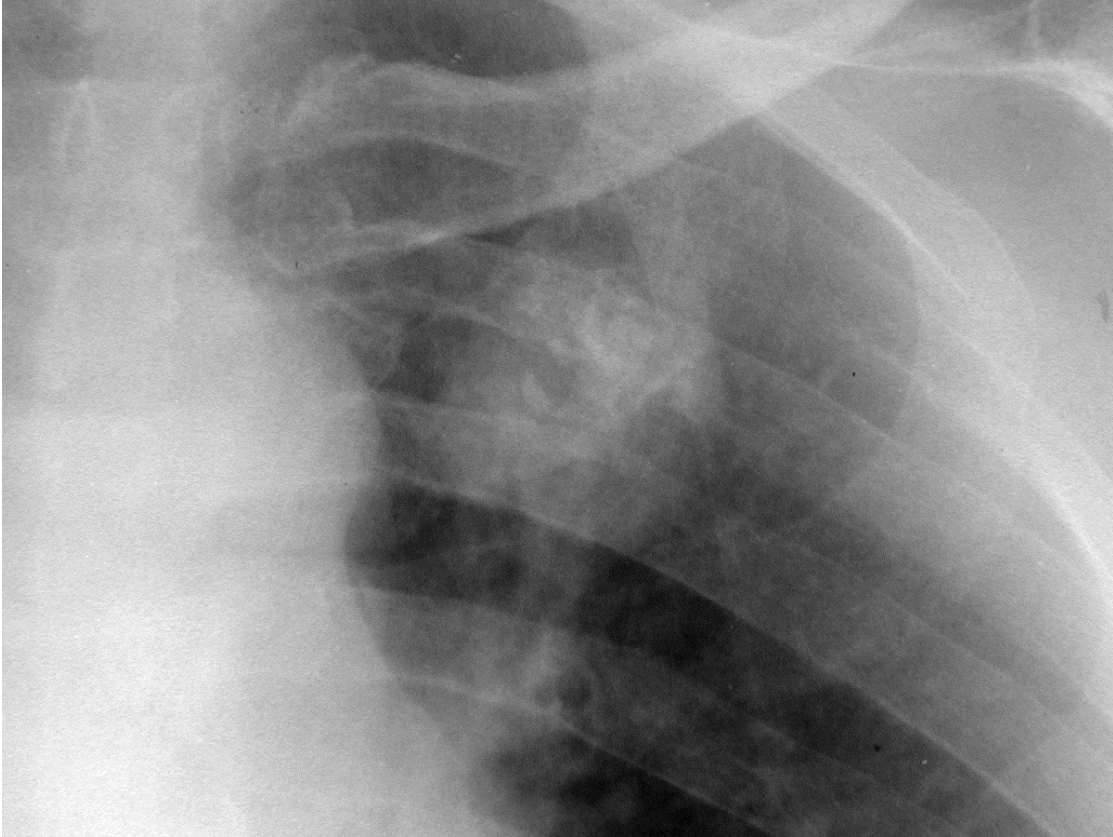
shows an enlarged view of the lesion. What is the main finding on the chest radiograph? How would you describe the finding?
